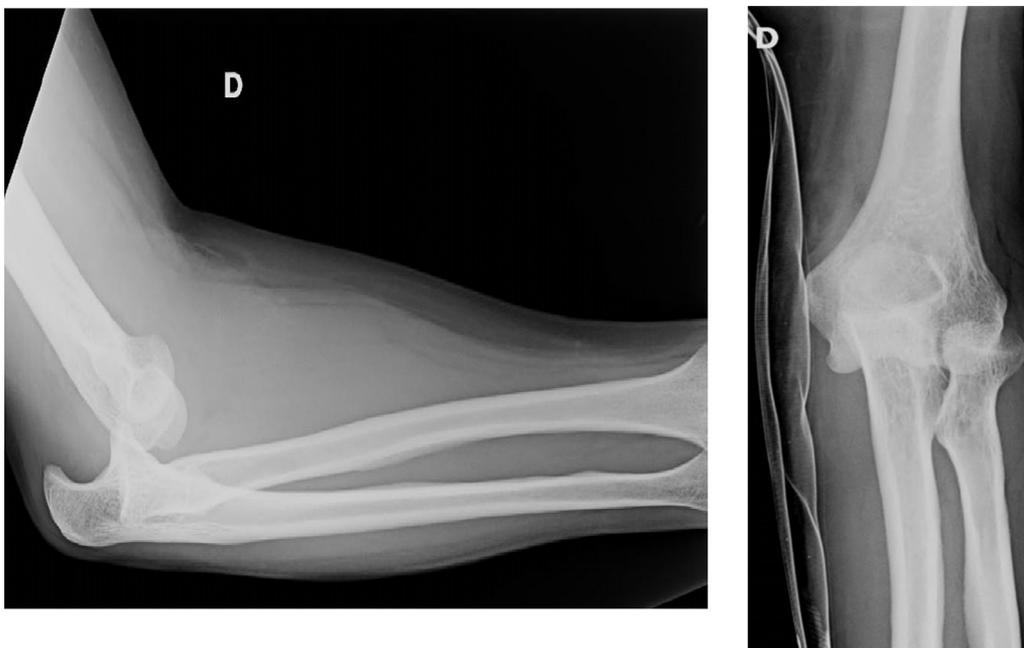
Anteroposterior and lateral x-rays from the initial evaluation showing a right posterolateral elbow dislocation.
